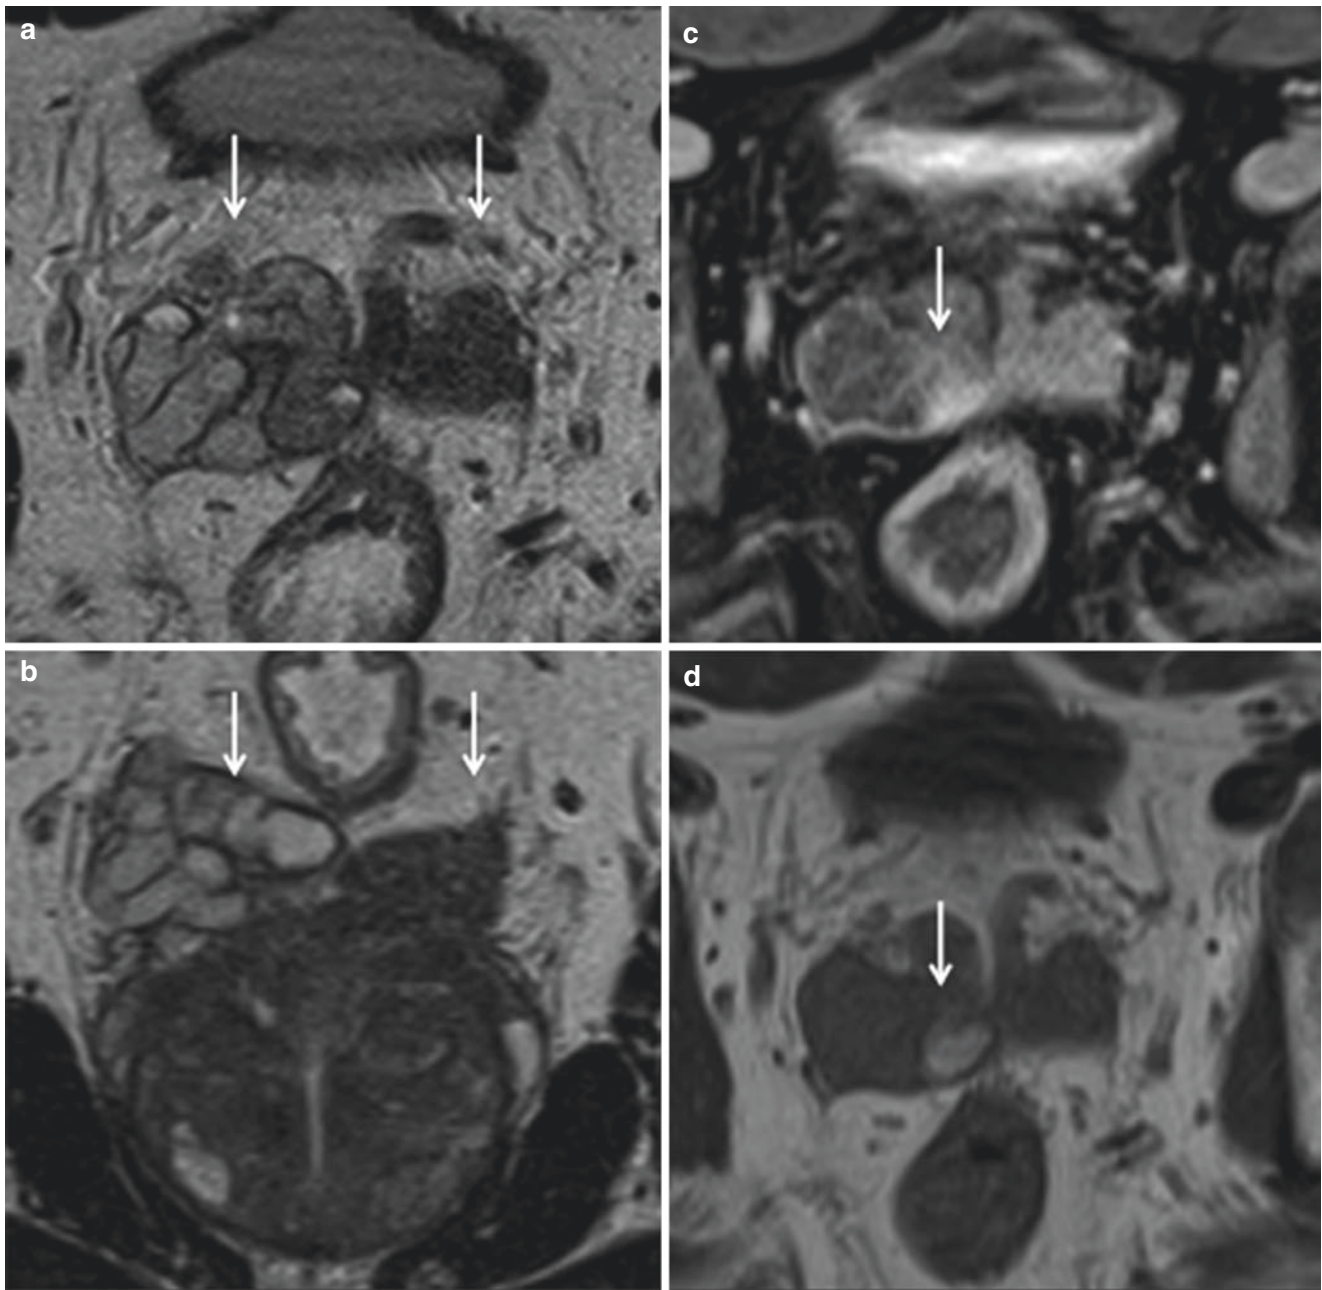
Seminal vesiculitis in a 30-year-old man with hematospermia. Axial (a), coronal (b) T2-weighted MR image and axial (c) contrast-enhanced fat-suppressed T1 weight MR image through the SV
